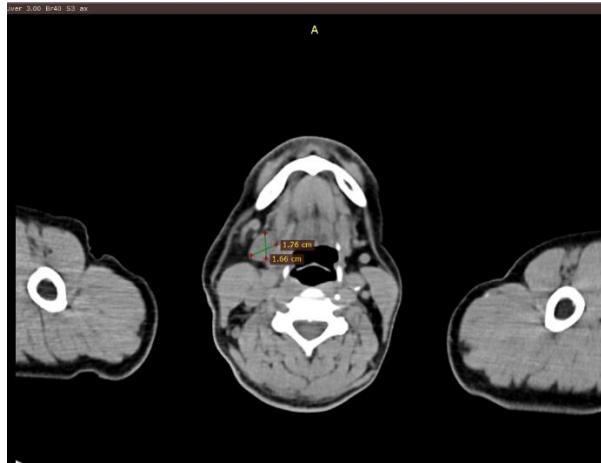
CT images of the neck extranodal infiltration
